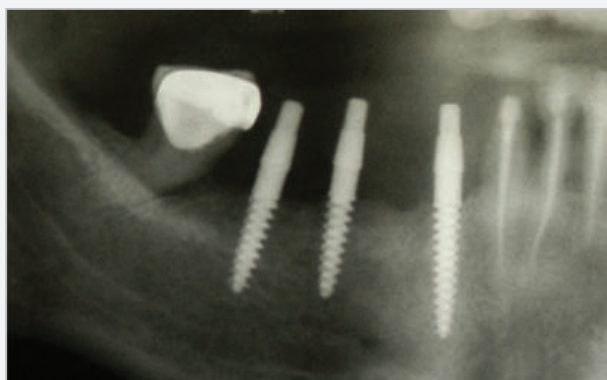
Postoperative x-ray with 2 3mm diameter, length 10mm, and one 13mm, 3mm diameter UNO implants.
